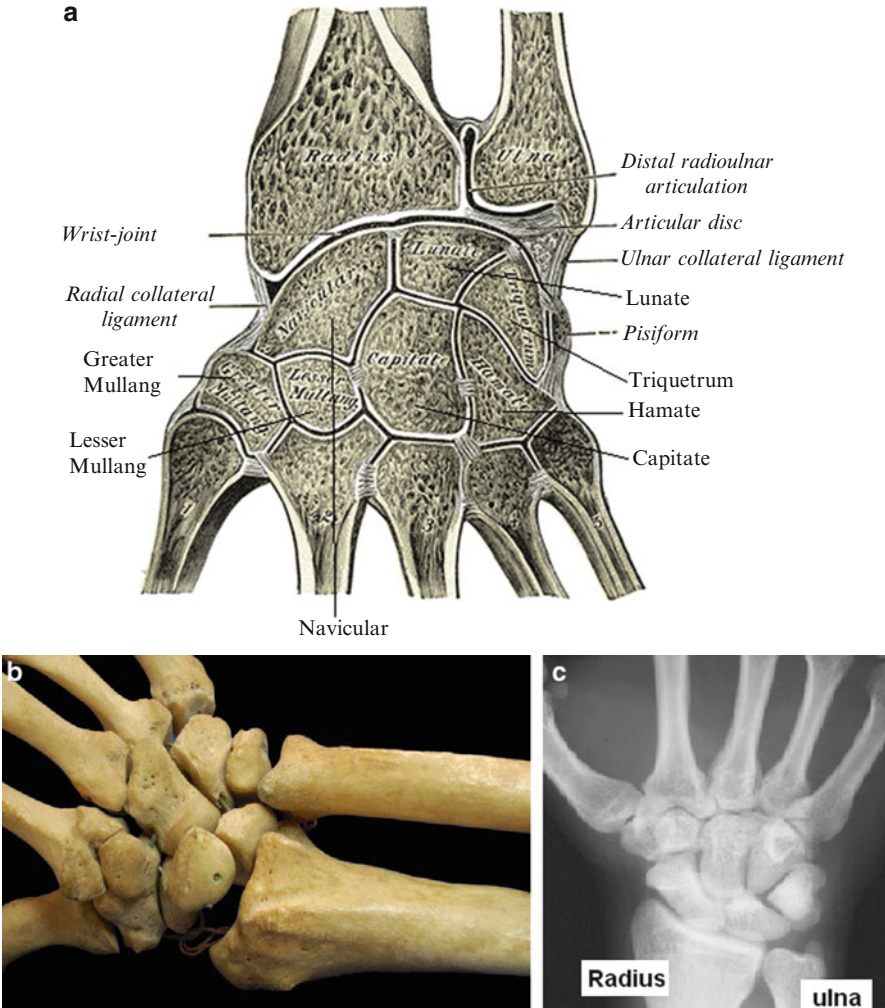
(a) Wrist joint features; (b) the bones; and (c) the X-ray view
